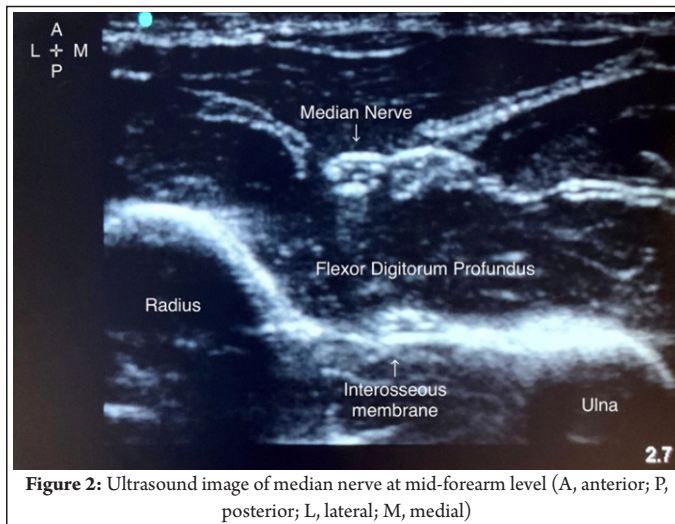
Ultrasound image of median nerve at mid-forearm level (A, anterior; P, posterior; L, lateral; M, medial)
